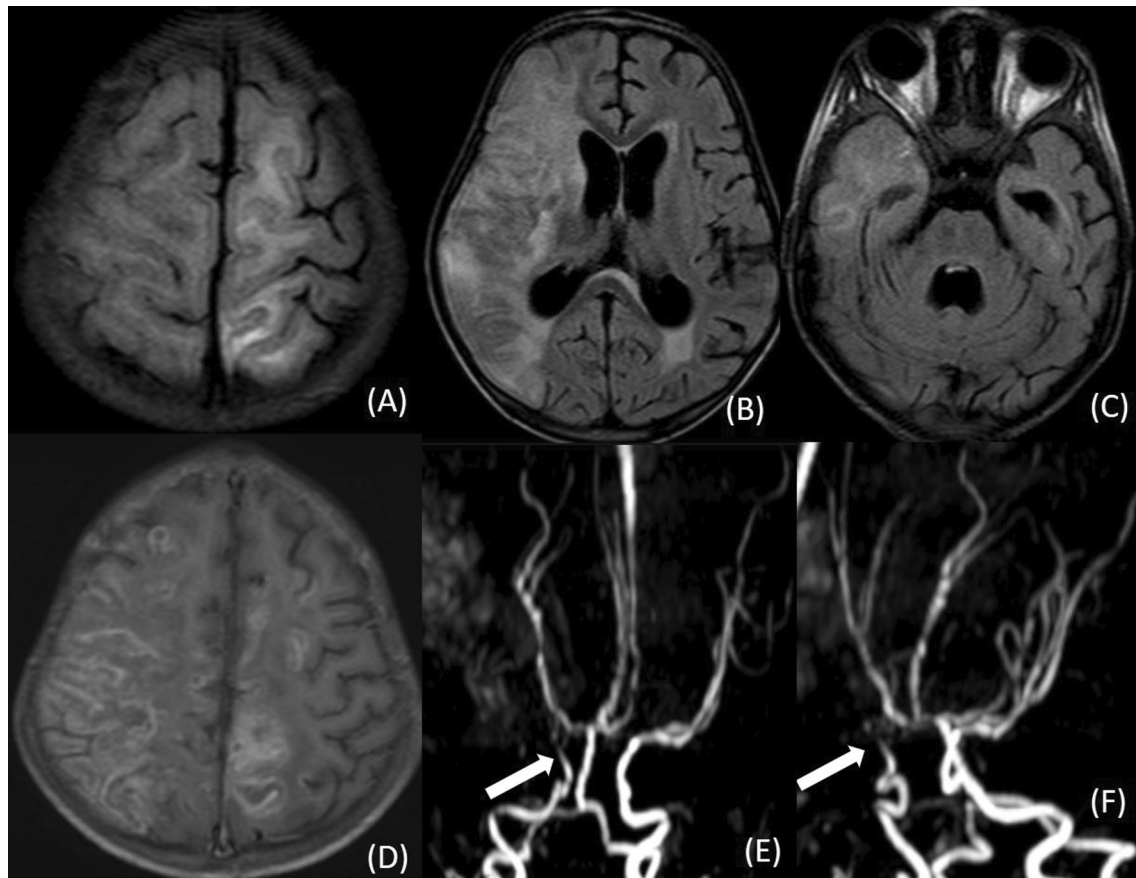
CNS TB with moyamoya vasculopathy. MRI of a 4-year-old boy shows hyperintensity involving both grey and white matter in bilateral ACA and right MCA territory on FLAIR images (A–C), T1 contrast-enhanced image shows leptomeningeal enhancement in bilateral ACA territory- ivy sign (D). MR angiography (E, F) shows near-complete occlusion of supraclinoid segment of right ICA and attenuation of supraclinoid segment of left ICA
